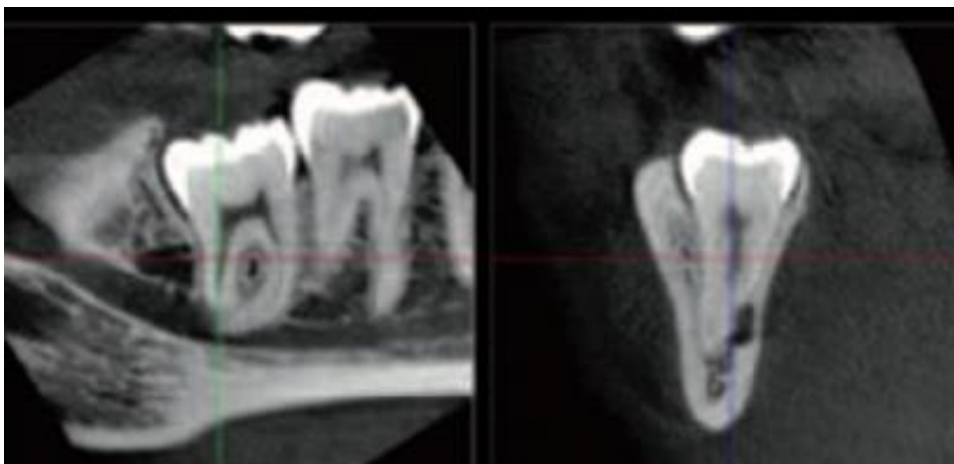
CBCT views showing concealment of the ID canal by the third molar roots (left) and decortication of the lingually positioned ID canal (right)
